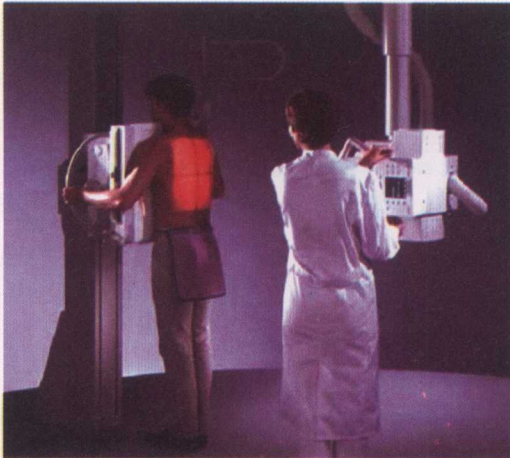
The posteroanterior posture of standard chest X-ray examination
